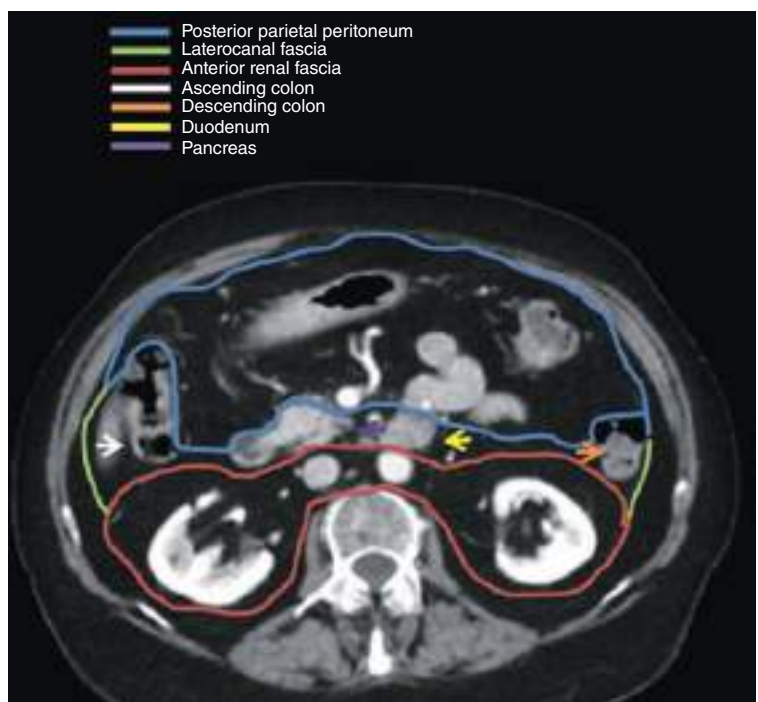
Peritoneal and retroperitoneal spaces. Axial contrast-enhanced CT image (portal venous phase).
